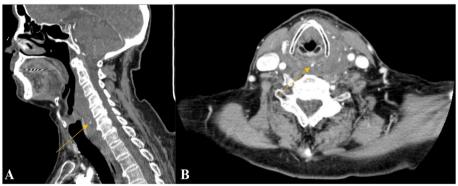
CT scan of retropharyngeal hematoma with spot-sign (arrow) in sagittal (A) and axial (B) cuts
